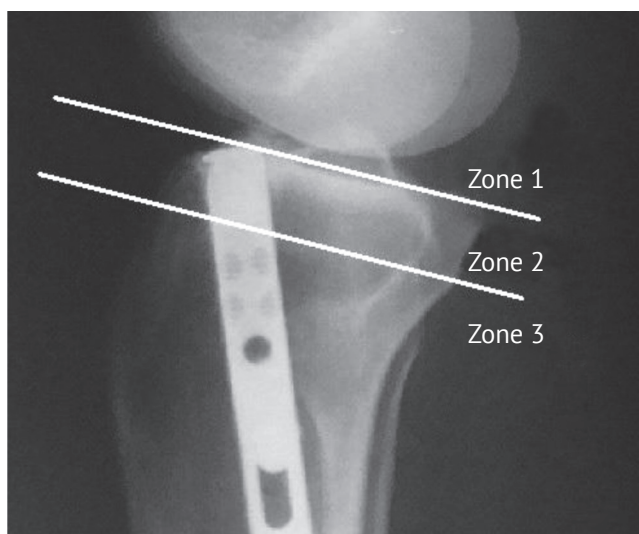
X-ray of the knee in lateral projection with three areas marked by lines
